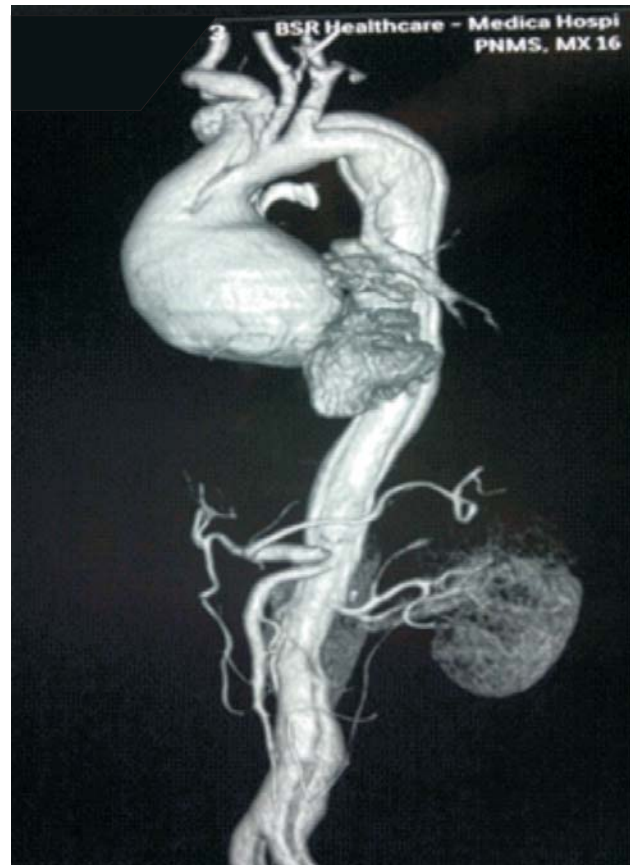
CT angio showing dissection of aorta starting from ascending aorta and extending through thoracic and abdominal aorta upto bilateral common iliac artery.
